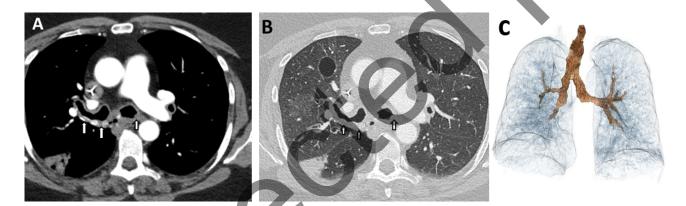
Axial chest CT images at the main bronchi level using A) mediastinum and B) lung window settings reveal irregular, nodular thickening of the bronchial walls along with submucosal calcifications (arrows). C) Three dimensional volume rendering chest CT image demonstrates luminal irregularities along the large airways (arrows).
